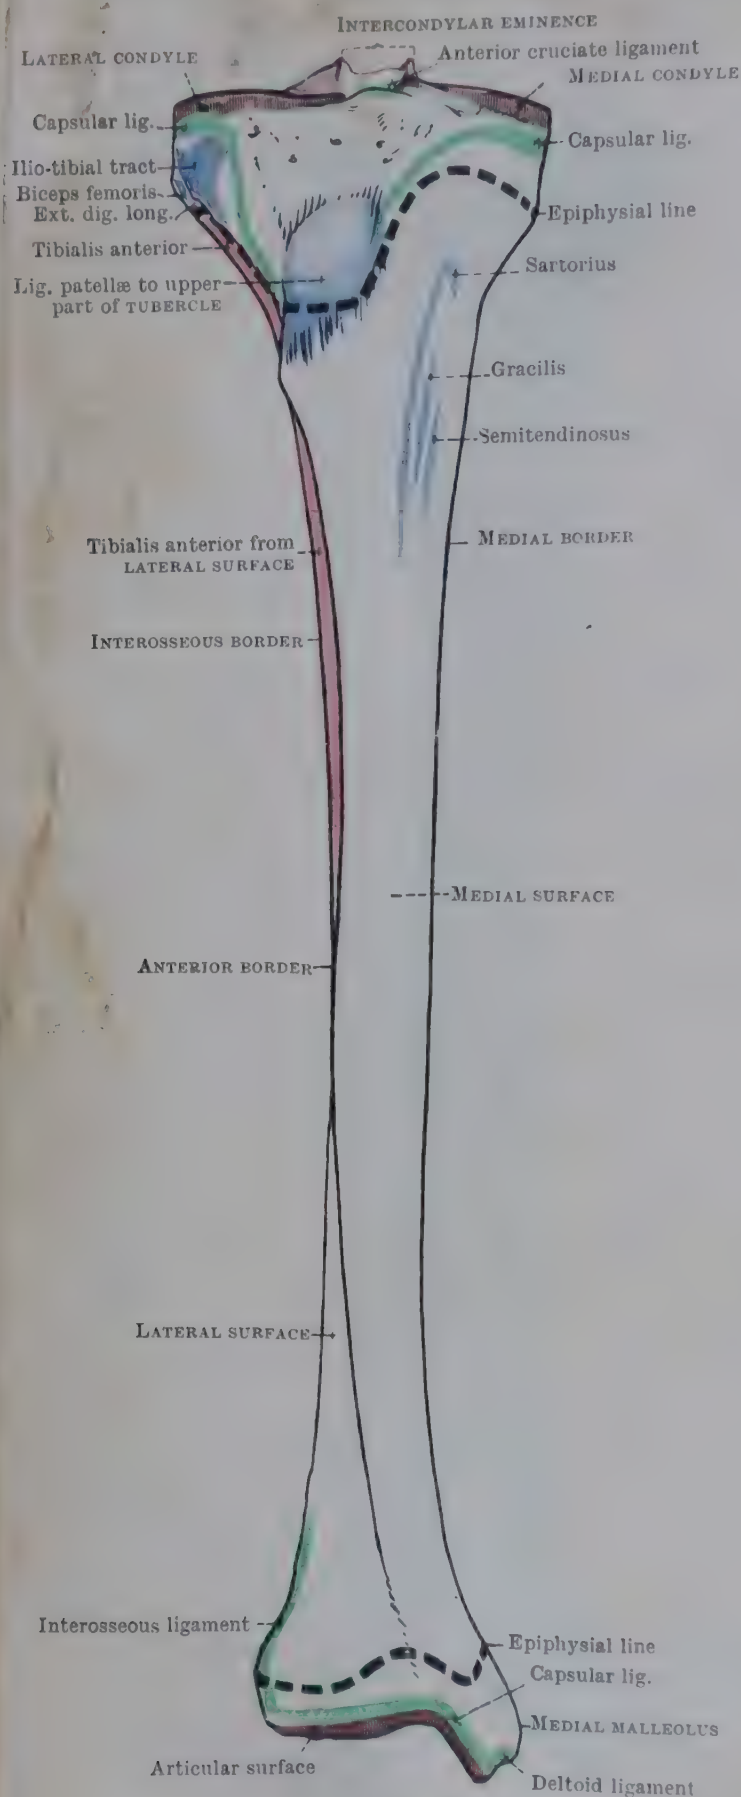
ANTERIOR ASPECT OF RIGHT TIBIA.
